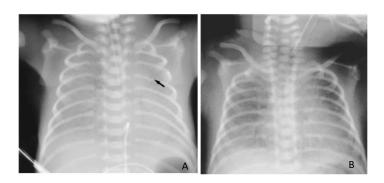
Chest X-ray appearance of respiratory distress syndrome before and after surfactant replacement
